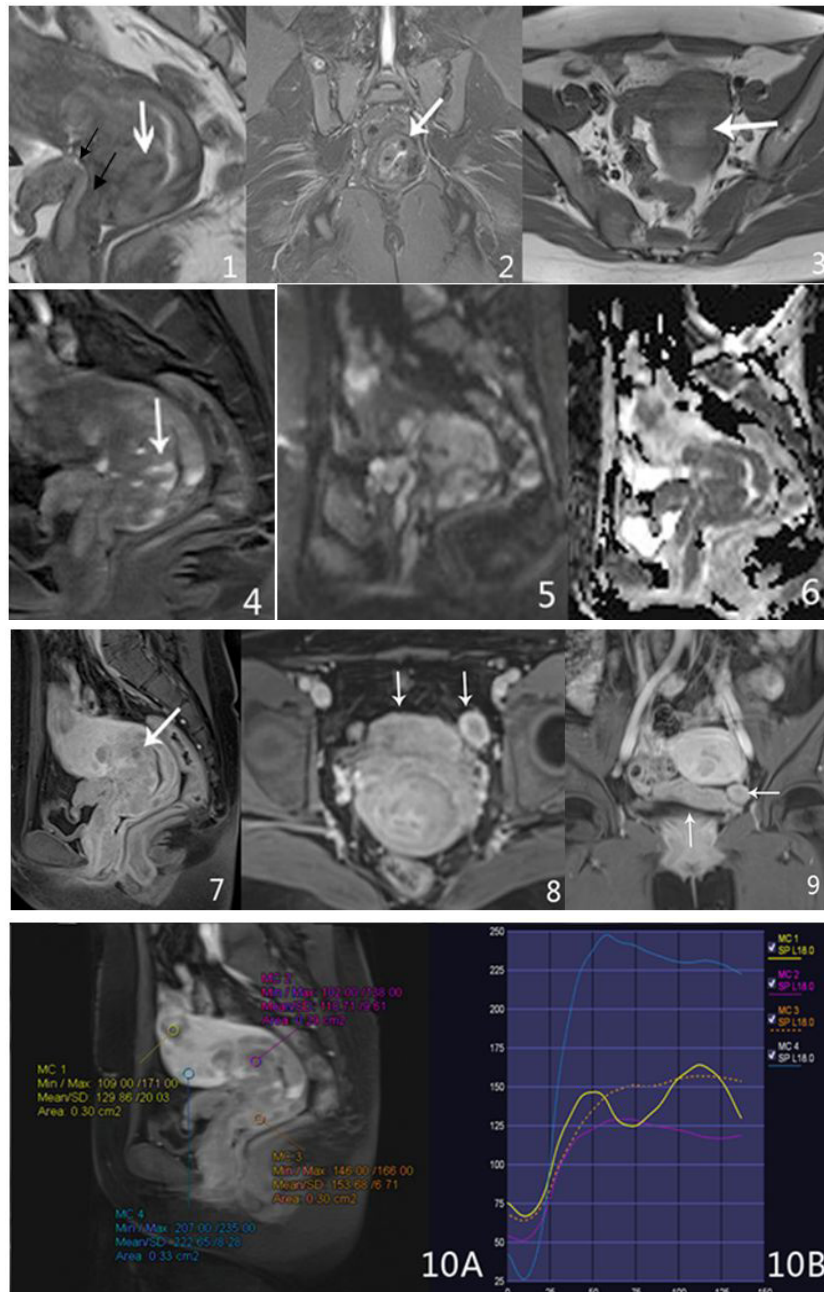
MRI examinations performed with 3.0T superconducting MRI systems
